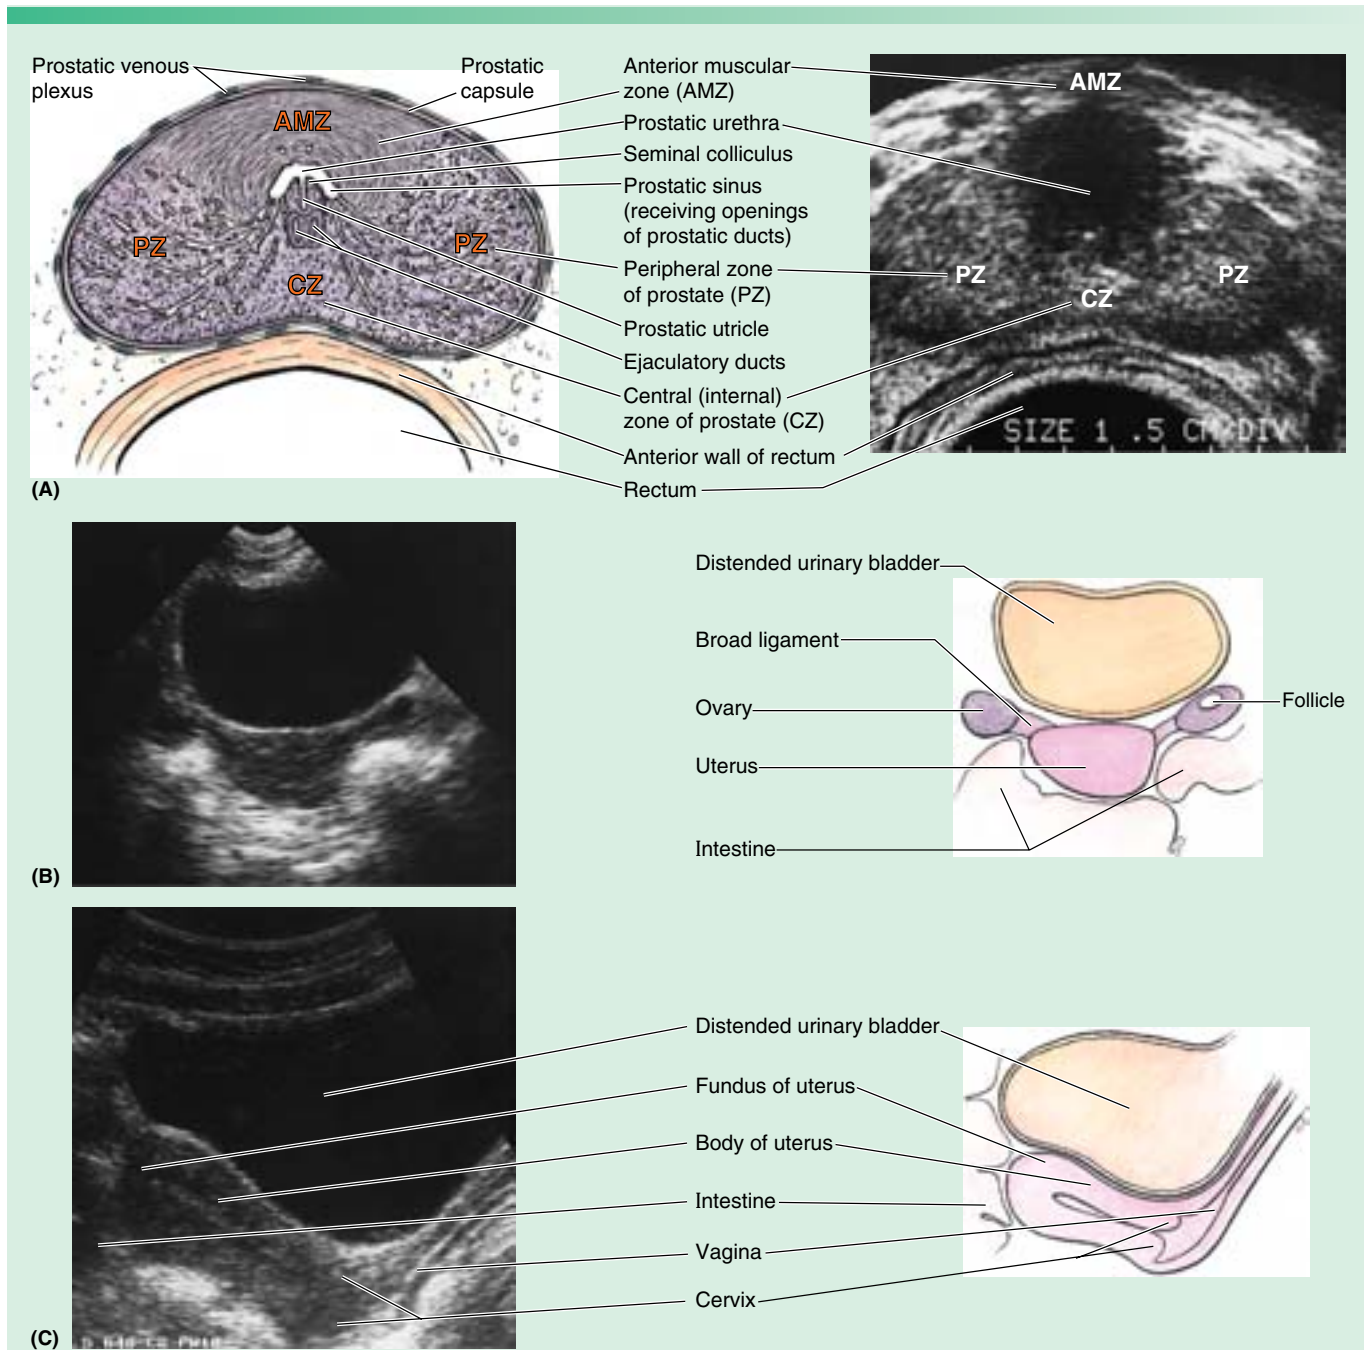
Ultrasound scans. A. In this transverse (transrectal) scan, the probe was inserted into the rectum to scan the anteriorly located prostate. The ducts of the glands in the peripheral zone open into the prostatic sinuses, whereas the ducts of the glands in the central (internal) zone open into the prostatic sinuses and the seminal colliculus. B. A transverse scan of a female’s pelvis is shown. C. A sagittal scan is shown. (Courtesy of Dr. A. M. Arenson, Assistant Professor of Medical Imaging, University of Toronto, Toronto, ON, Canada.)
